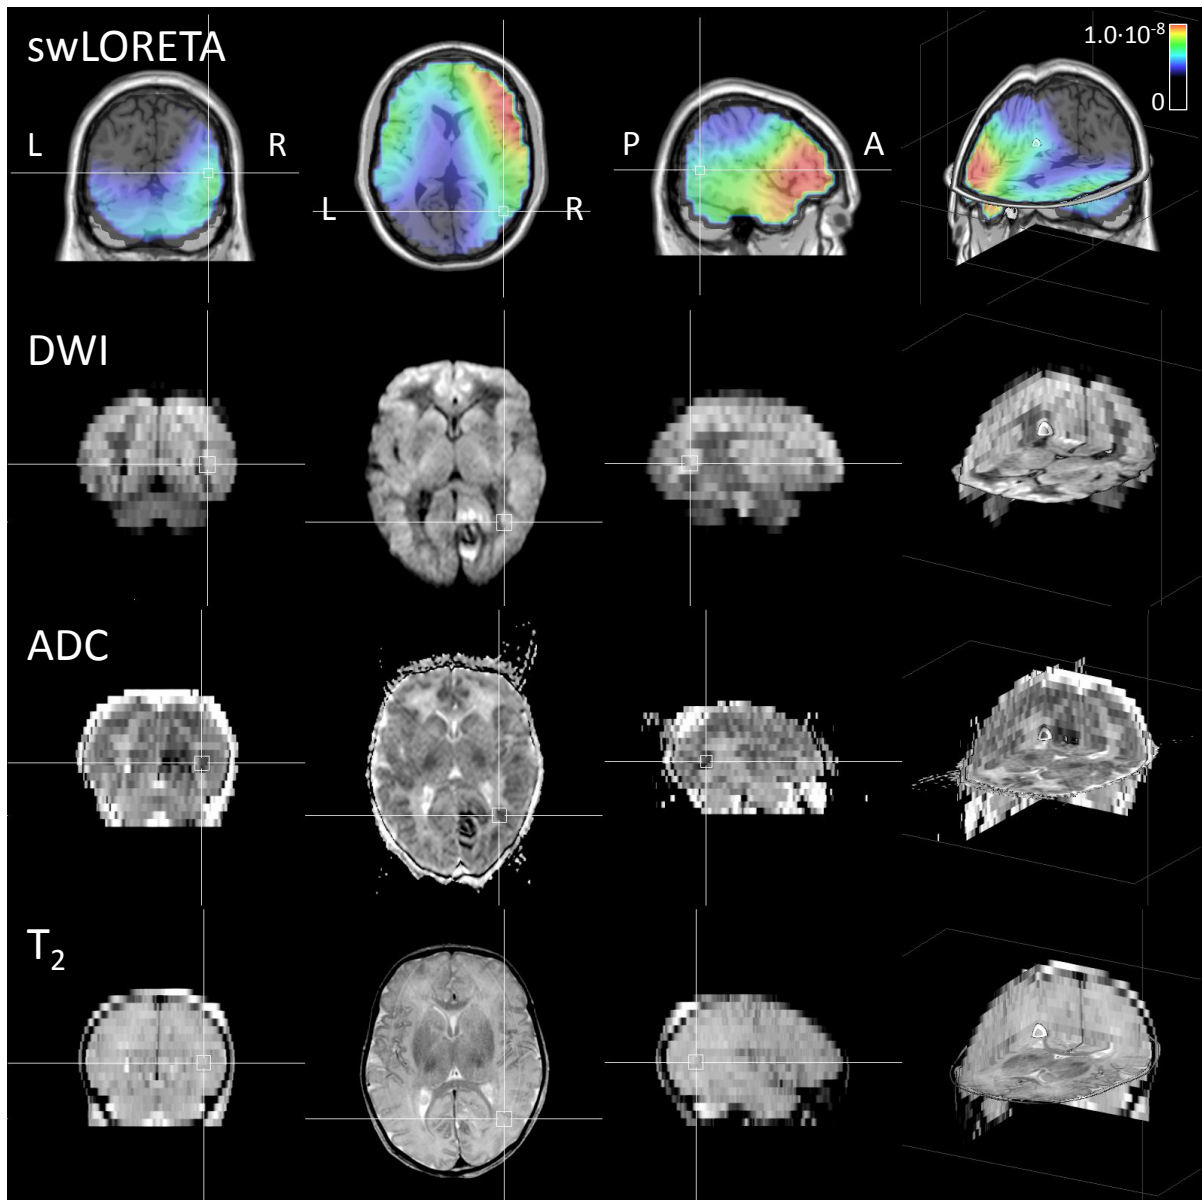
MRI images of patient 2 (DWI, ADC, T_2) displayed together with the swLORETA inverse solution. The inverse solution indicates that most EEG activity is situated in the right frontal and temporal lobes. The focal hemorrhage in the right occipital region as visible in the MRI is not observed in the inverse solution.
